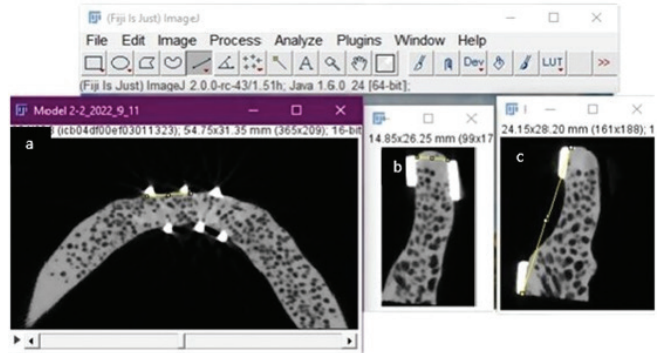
CBCT linear measurement of the model width (a), thickness (b) and height (c)
